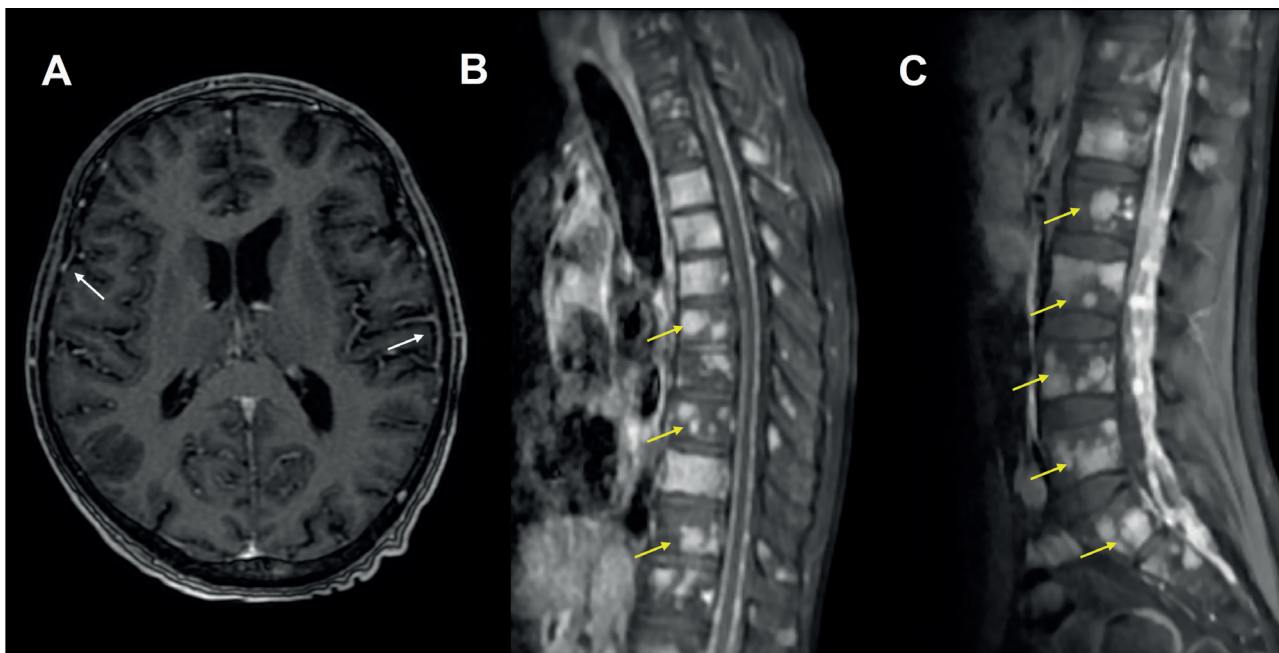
Case-2. (A) Contrast-enhanced MRI of brain. Contrast-enhanced T1-weighted axial image. Showed leptomeningeal involvement (white arrow). (B) Contrast-enhanced thoracic spine MRI. T1-weighted sagittal image (yellow arrow). (C) Contrast-enhanced lumbar spine MRI. T1-weighted sagittal image. Showed multiple bone metastases (yellow arrow).
